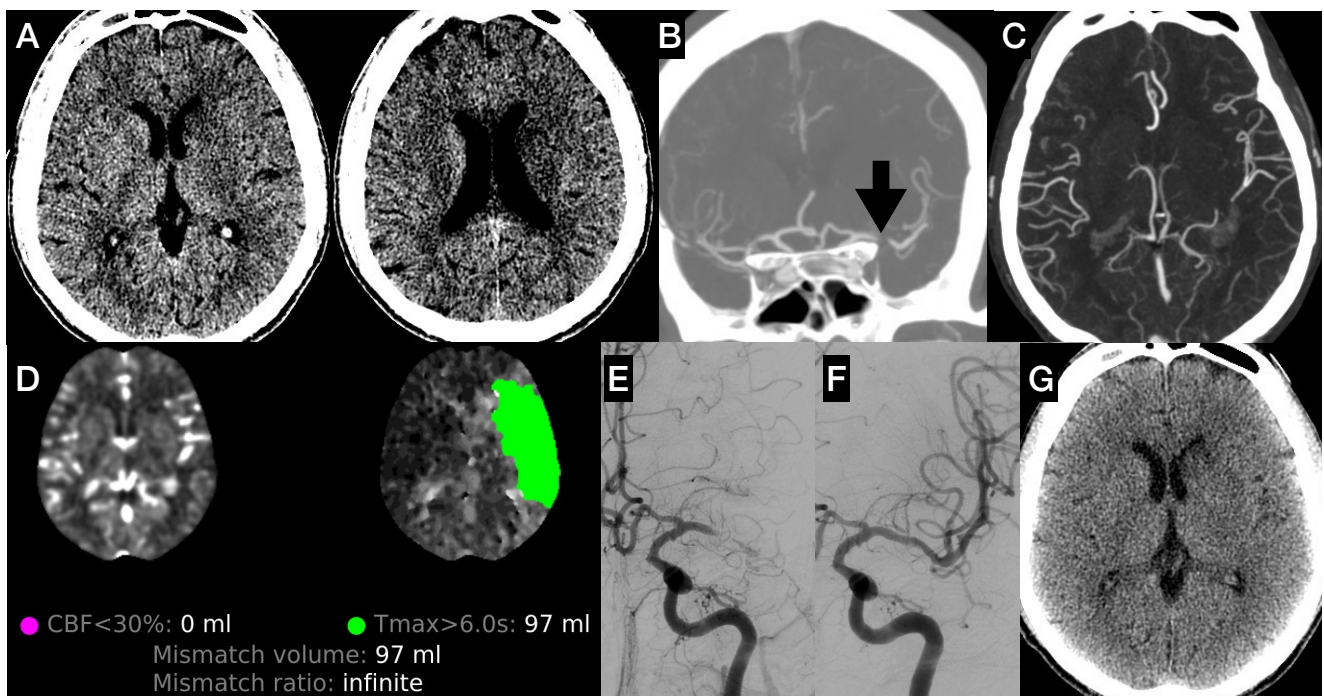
A 47 years old patient presented right-sided weakness for 6 hours, NIHSS = 11 A: NECT of the brain showed a hypodense area in the head of the left caudate nucleus, left internal capsule and left lentiform nucleus, with an ASPECTS score = 7. B: CTA source image shows total occlusion of the M1 segment of left MCA (black arrow). C: Multi-phase CTA during the 1st phase shows a collateral score = 5. D: CT perfusion shows no core infarct with a ischemic penumbra area about 97 ml, resulting in a mismatch ratio = infinite. Based on the DEFUSE-3 criteria from CT perfusion, the patient underwent MT E: Left ICA angiogram shows nearly total occlusion of the M1 segment of the left MCA. F: Post-MT left ICA angiogram shows recanalization of the left MCA. G: Brain CT, 24 hours post-MT shows subacute infarction in the head of left caudate nucleus but no hemorrhagic transformation. The patient exhibited improvement in weakness, NIHSS = 3. At the 3-month follow-up, the patient showed mRS = 0.
